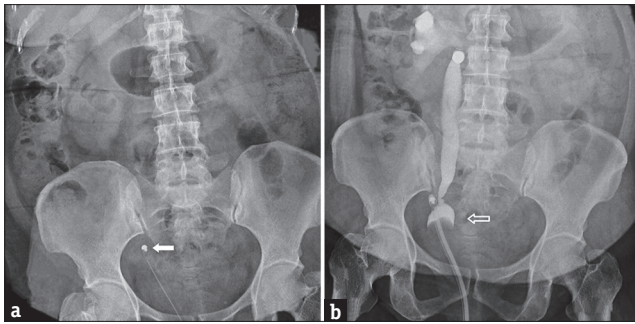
A 47-year-old female underwent transvaginal repair for vesicovaginal fistula acquired after a hysterectomy. (a) Plain X-ray of kidney, ureter, and bladder region shows deviation of the tip of the Foley's catheter toward the right side pelvic wall (white solid arrow). (b) Filling cystogram showing the presence of inflated Foley's catheter (hollow white arrow) inside the lower part of the right ureter with pyelogram and extravasation of the contrast agent around the kidney.
